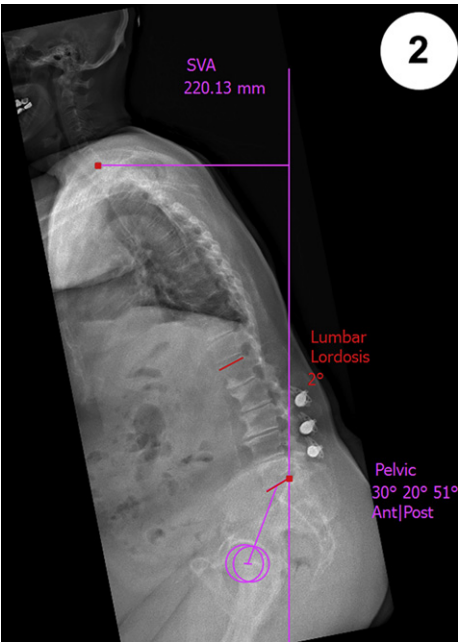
The second phase of the graphical surgical planning consists in rotating (in this case counterclockwise) the sagittal radiograph until a desired planned pelvic tilt is reached (here 20°).
